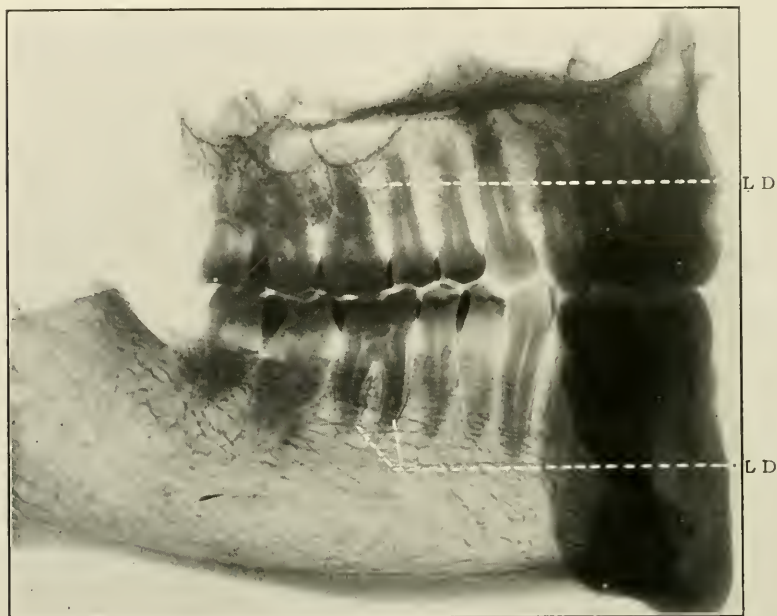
Radiograph of right side of jaws of man aged forty-five years, showing at L.D. the *lamina dura*.
